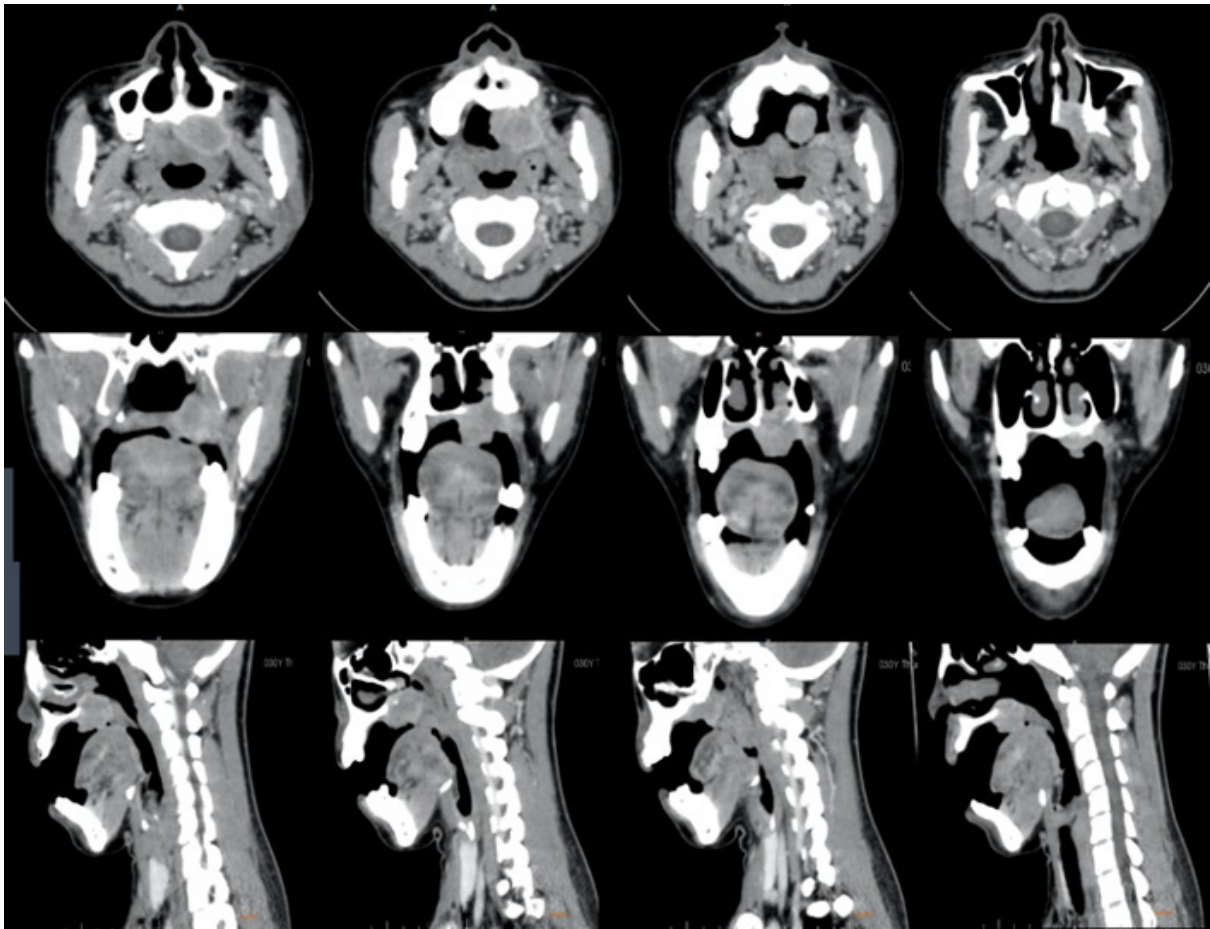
Facial and neck CT-scan with IV contrast.
